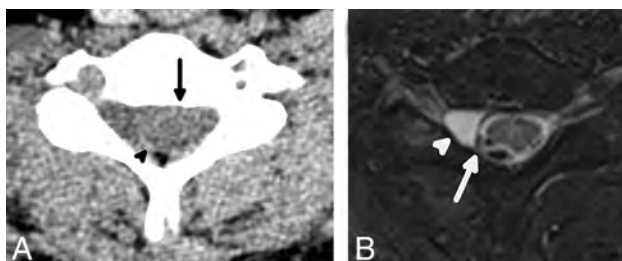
A 26-year-old man with preganglionic BPI and eccentricity of the spinal cord. An axial CT image (A) shows subtle eccentricity of the spinal cord and thecal sac (arrow) with an asymmetric amount of CSF in the right aspect of the spinal canal, which is indicative of a pseudomeningocele. There is also thin extra-axial hemorrhage (arrowhead) along the posterior aspect of the spinal cord. An axial T2 STIR MR imaging performed a day later in the same patient (B) shows complete avulsion of the ventral and dorsal nerve rootlets with eccentricity of the spinal cord (arrow), which is lateralized to the left of the spinal canal, compatible with preganglionic BPI. A small pseudomeningocele is confirmed on MR imaging (arrowhead) and is a finding highly associated with nerve rootlet avulsion.
